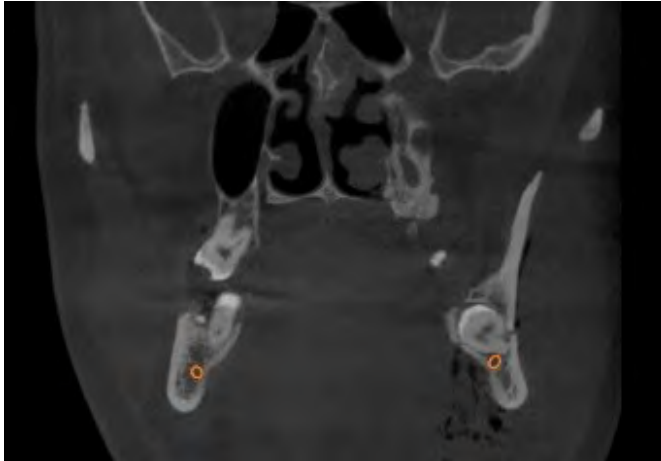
CBCT coronal section view
